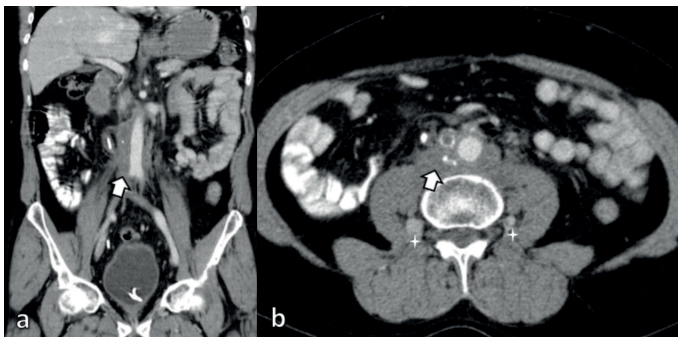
On coronal and axial contrast enhanced abdomen CT images (a, b) you can see complete obstruction of IVC because of malignancy (white arrows). (b) Be aware of enlarged lumbar venous collateral pathways (white stars).
